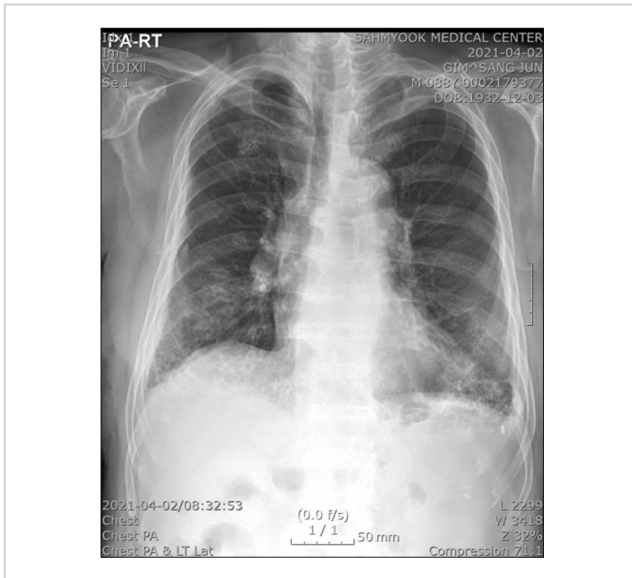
Chest radiograph shows no evidence of pneumonia, except for persistent interstitial infiltrates due to chronic idiopathic pulmonary fibrosis.
